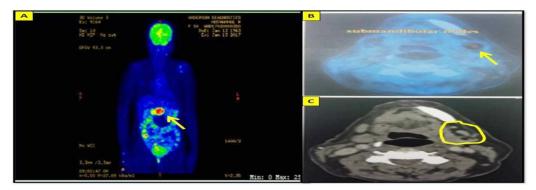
A) Whole body PET-CT scan showed metabolic activity in portocaval, peripan creatic. (Arrow) B) & C) Metabolic activity in submandibular lymph nodes confirming a clinical stage III disease (Arrow and marking)
